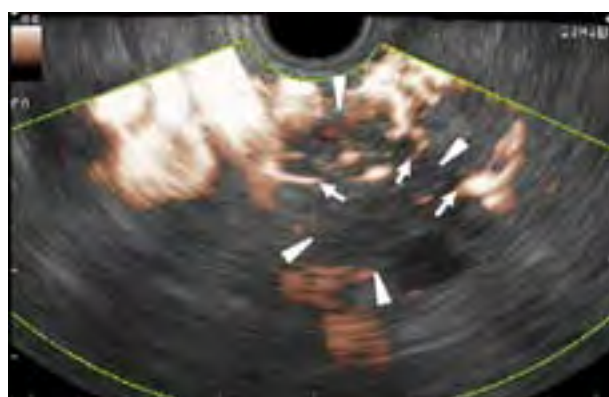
Contrast-enhanced directional eFLOW imaging in a pancreatic carcinoma. Endoscopic ultrasound with contrast-enhanced directional eFLOW imaging shows a hypoechoic tumor (arrowheads) at the pancreas head. Irregular vessels (arrows) are observed at the periphery of the tumor with fewer blooming artifacts. Color signals are fewer in the center of the tumor than in the periphery.
